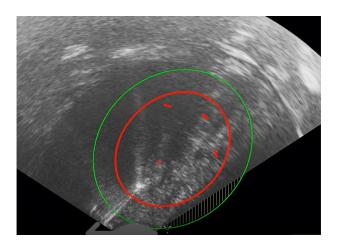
Intraoperative intrauterine sonography and ablation with the transcervical ultrasound-guided radiofrequency system.
